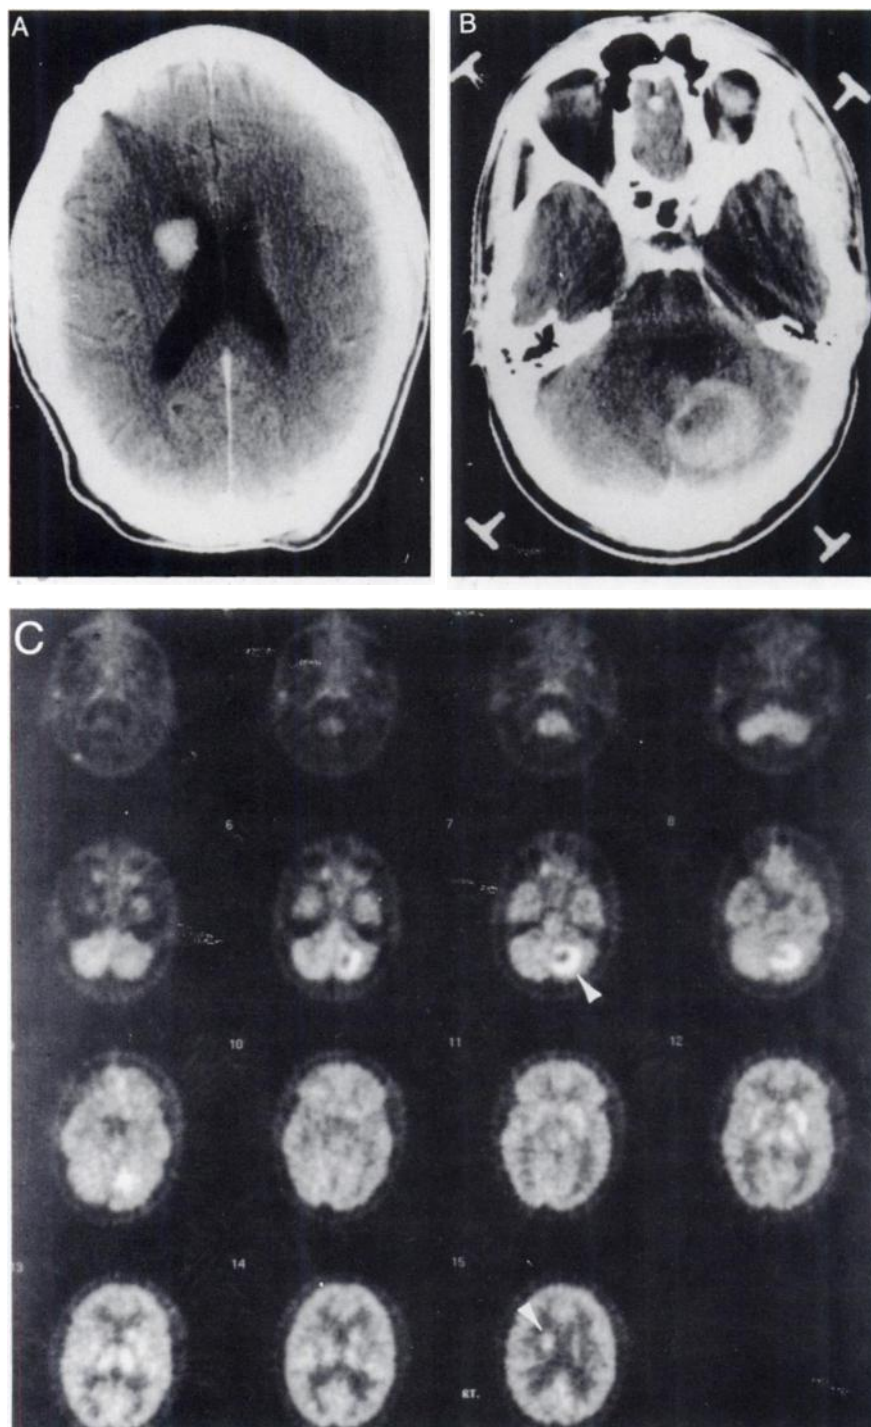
Patient 11 (Table 1). Contrast-enhanced CT at the level of the ventricles (A) shows an enhancing lesion in the superior head of the caudate region. On the same CT study, an enhancing ring lesion was noted in the left cerebellum (B). FDG-PET study (C) showed hypermetabolic lesions in the left cerebellum (arrow) as well as in the head of the right caudate (arrowhead). This patient had biopsy proven lymphoma.
